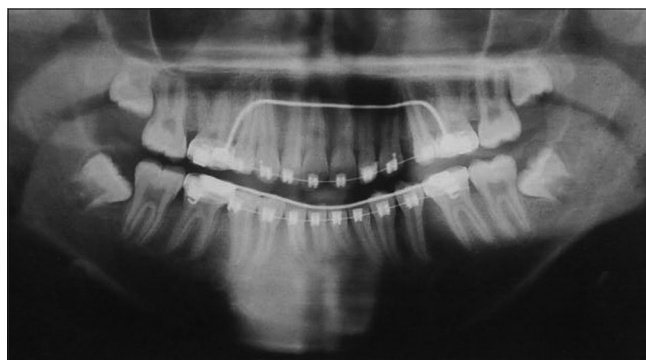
Orthopantomogram taken 3 years postextraction showing good dental alignment
